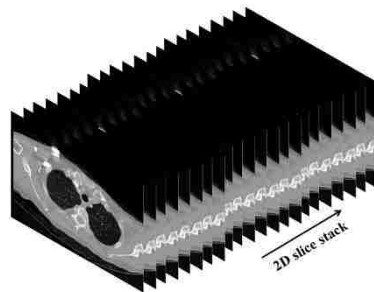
Two-dimensional slice stack of CT-scans constituting a 3D lung geometry.
